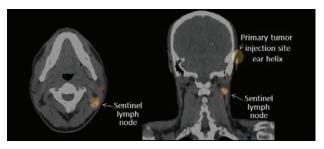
Head and neck SPECT-CT, prior to sentinel lymph node (SLN) excision, demonstrates a level IIb neck SLN in the submuscular triangle, deep to the sternocleidomastoid muscle and posterior to the internal jugular vein.
